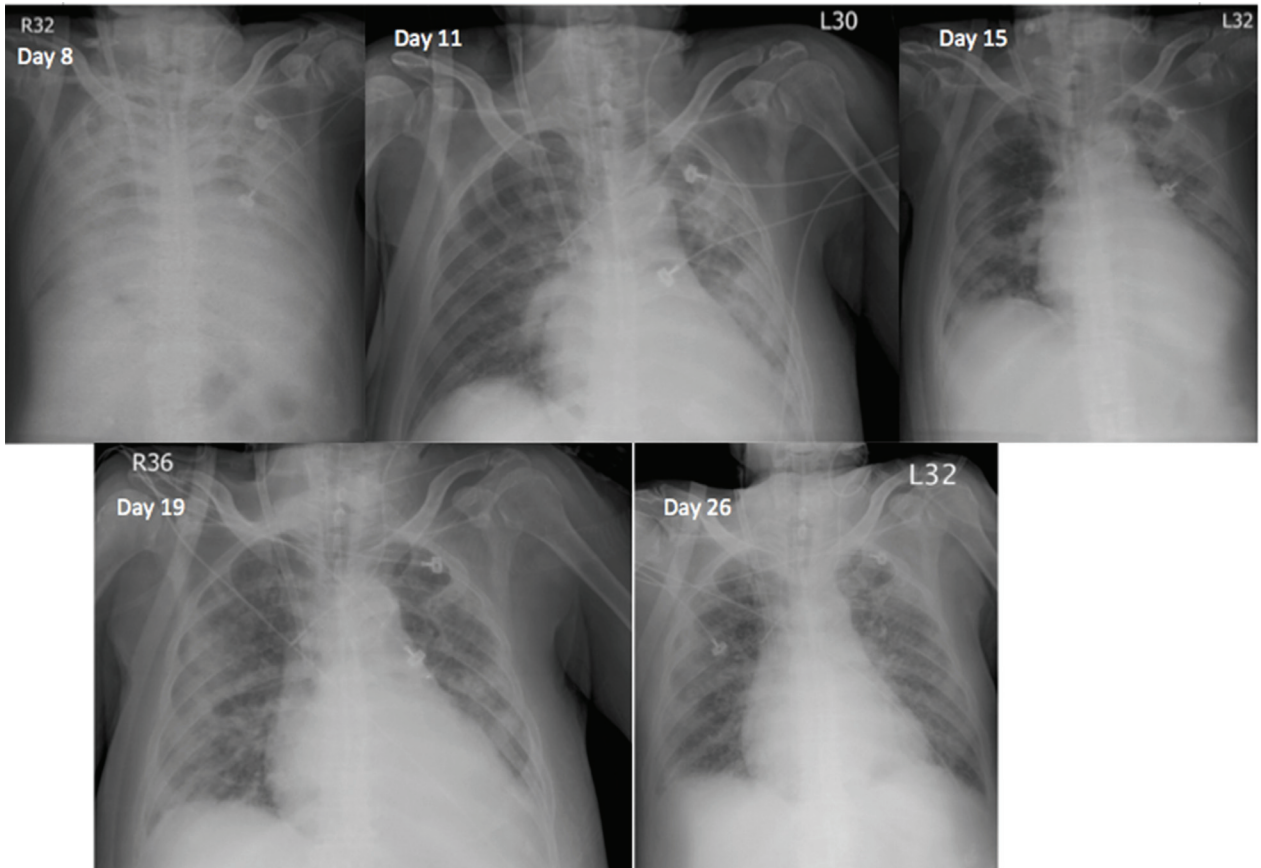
Chest X-ray images during treatment. Note the gradual improvement in bilateral infiltrates.
